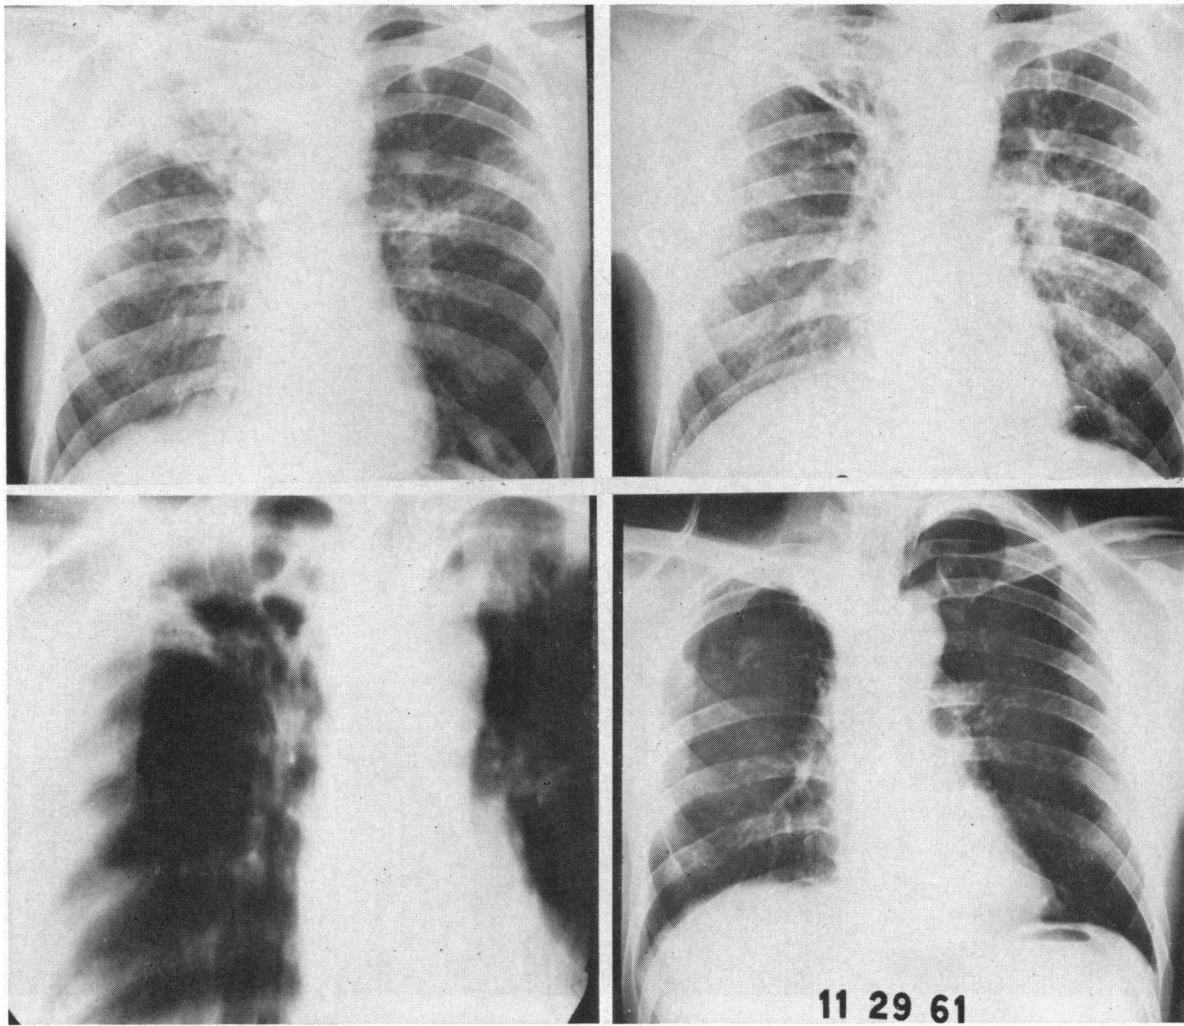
(Case 5). Picture at upper left is pretreatment roentgenogram showing far advanced bilateral pulmonary tuberculosis. At upper right is a roentgenogram taken after eight months of antituberculosis chemotherapy. The planigram at lower left, taken preoperatively, shows shrunken right upper lobe with cavitation. The picture at lower right is a postoperative roentgenogram taken three months after division of the right upper bronchus and three-rib thoracoplasty.
